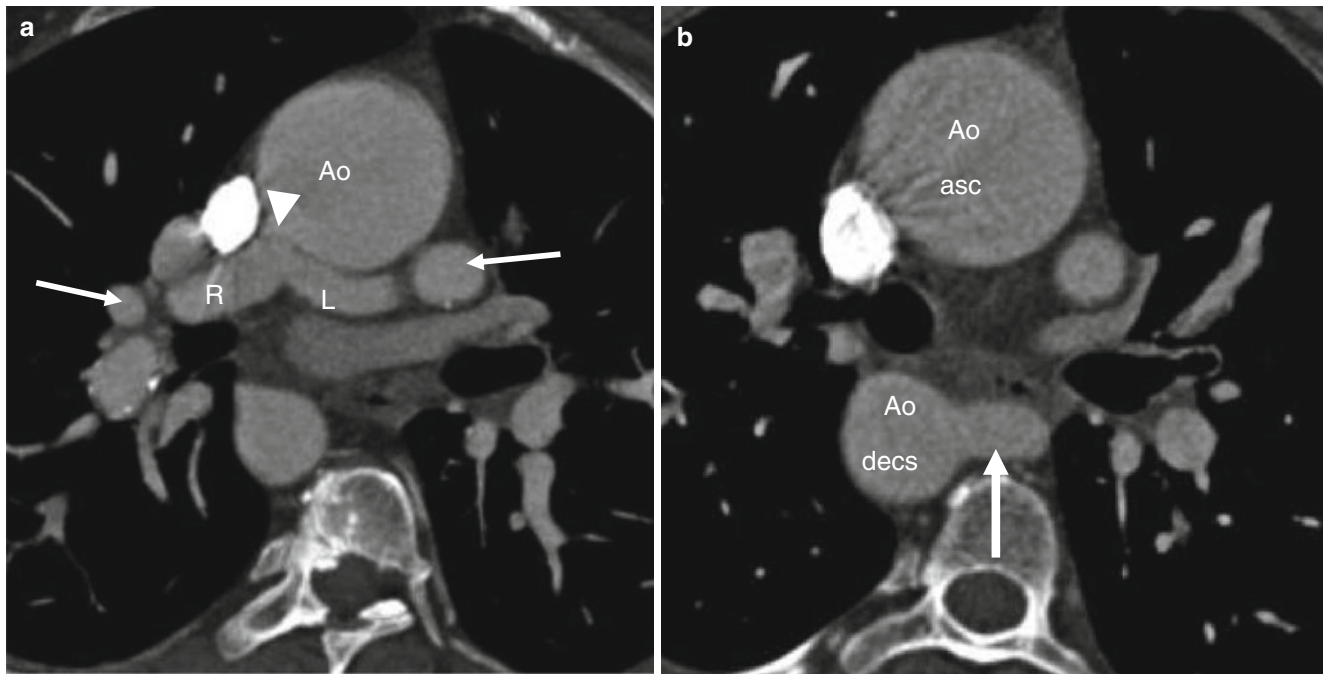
Type B pulmonary atresia with ventricular septal defect. A 40-year-old woman who underwent placement of a Waterston shunt at age 7 years and no additional surgical procedures. Panel (a) an axial computed tomography (CT) view shows separate branches of the left (L) and right (R) pulmonary arteries supplying the lungs. There are also
